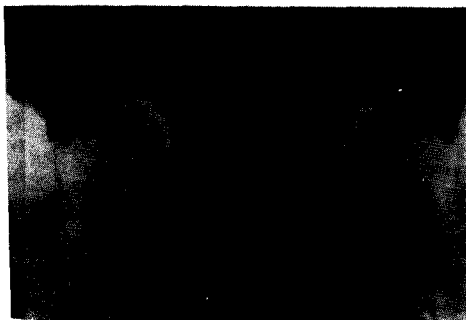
X-ray of both heels: lateral view shows spurs at the insertion of the both Achilles tendons and plantar aponeurosis bilaterally. Fracture spur is seen at the insertion of the right Achilles tendon.
